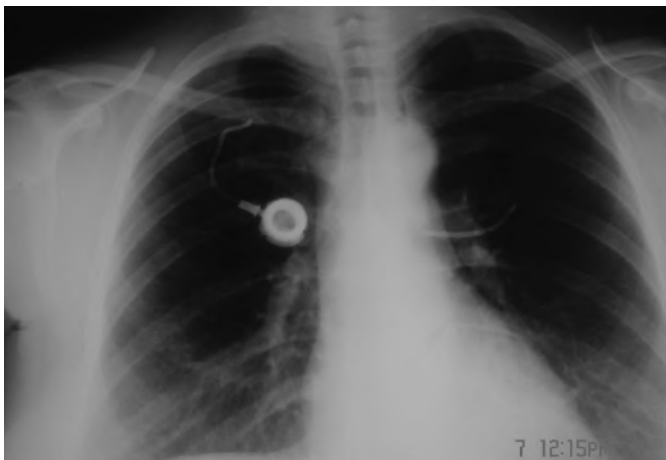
Chest x-ray. The port device is in the right position but the terminal part of the catheter is broken and had migrated into the left pulmonary vein.
